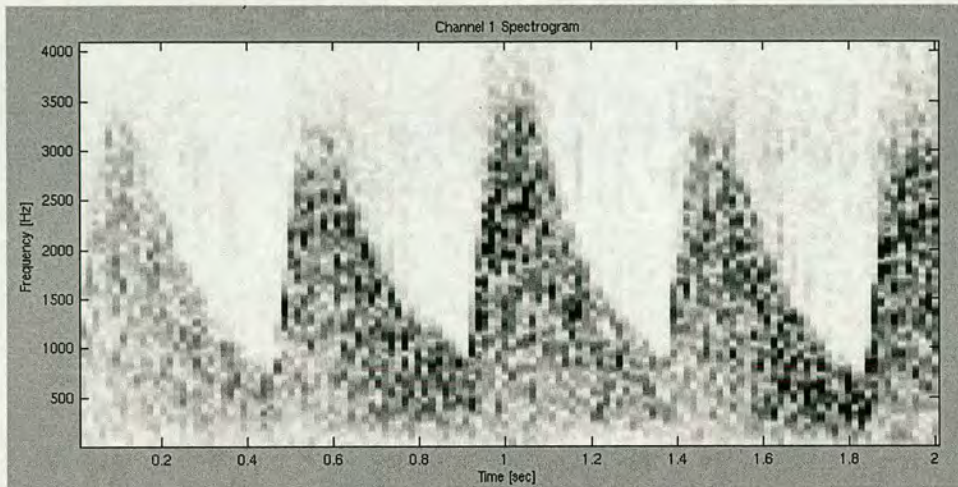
Example sonogram, generated from the signal received from blood flowing through the umbilical cord.
